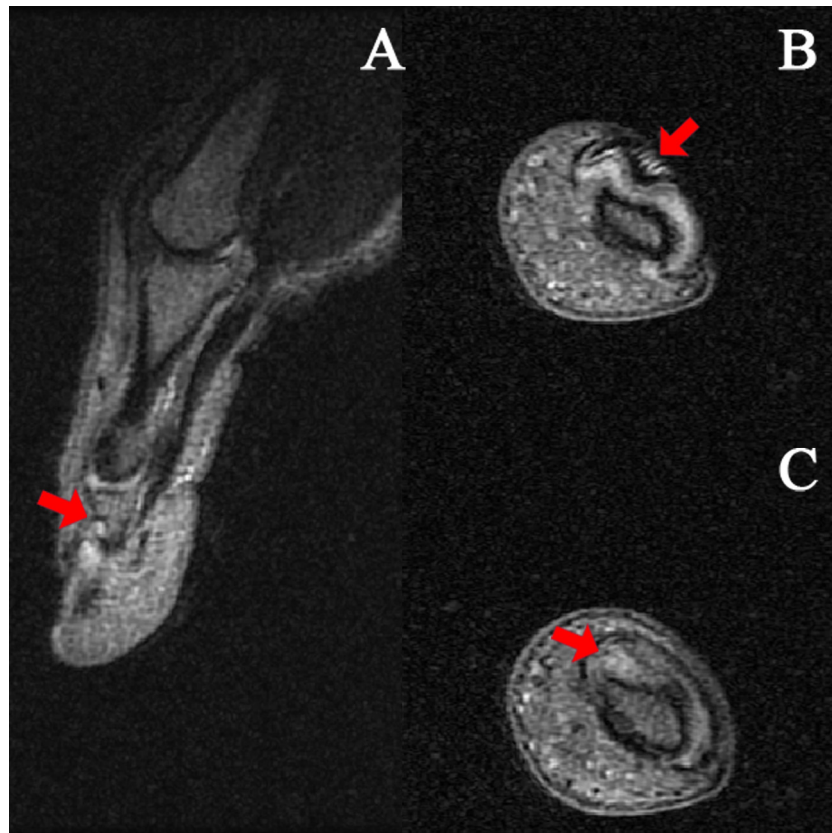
Fat-saturated proton density-weighted MRI of the thumb showing the $7.7 \times 6.9 \times 4.1$ -mm lesion. Longitudinal (A) and transverse (B and C) slices of the tumor arising from the ulnar side of the thumb's nail. It has a heterogeneous hypersignal on proton density fat-saturated images with fingerlike projections within its thickness.
